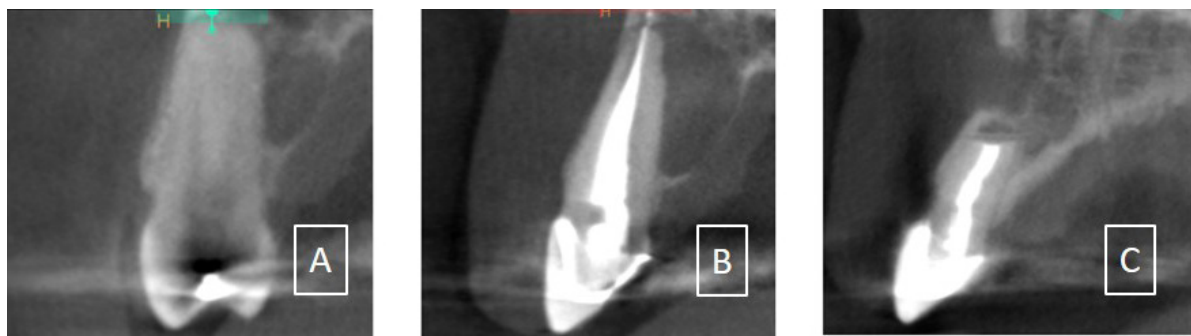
Coronal views of teeth numbers 12-14 sites from a CBCT taken after endodontic therapy on tooth 13 and tooth 12, as well as an apicoectomy on tooth 12. The images show loss of the buccal cortex, consistent with previous root end surgery, in tooth 12 site, as well as palatal expansion in tooth 13 site.
